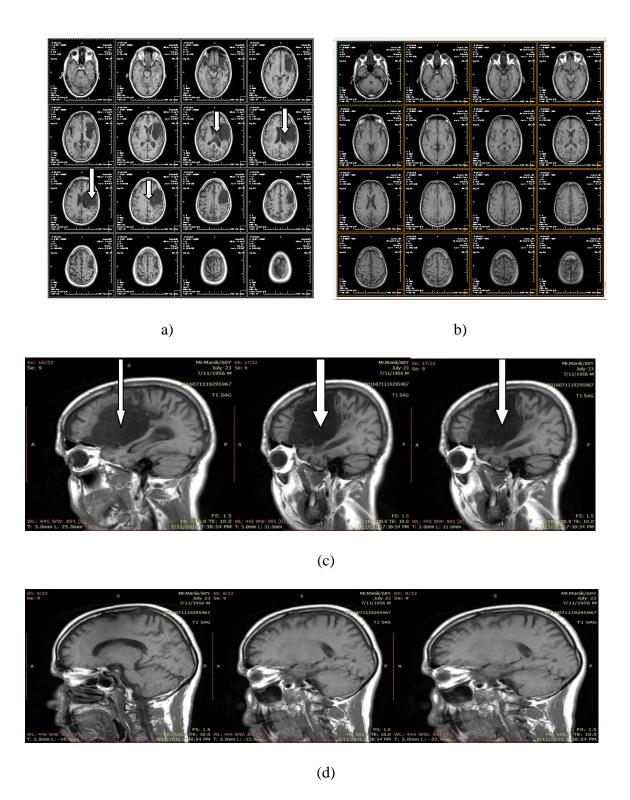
a) MRI findings of the patient showing an infarcted region b) MRI findings of the normal adult people c)Sagittal section of injured (left) hemisphere with a large infarct(d)Sagittal section of unaffected (right) hemisphere of the patient showing no pathology
